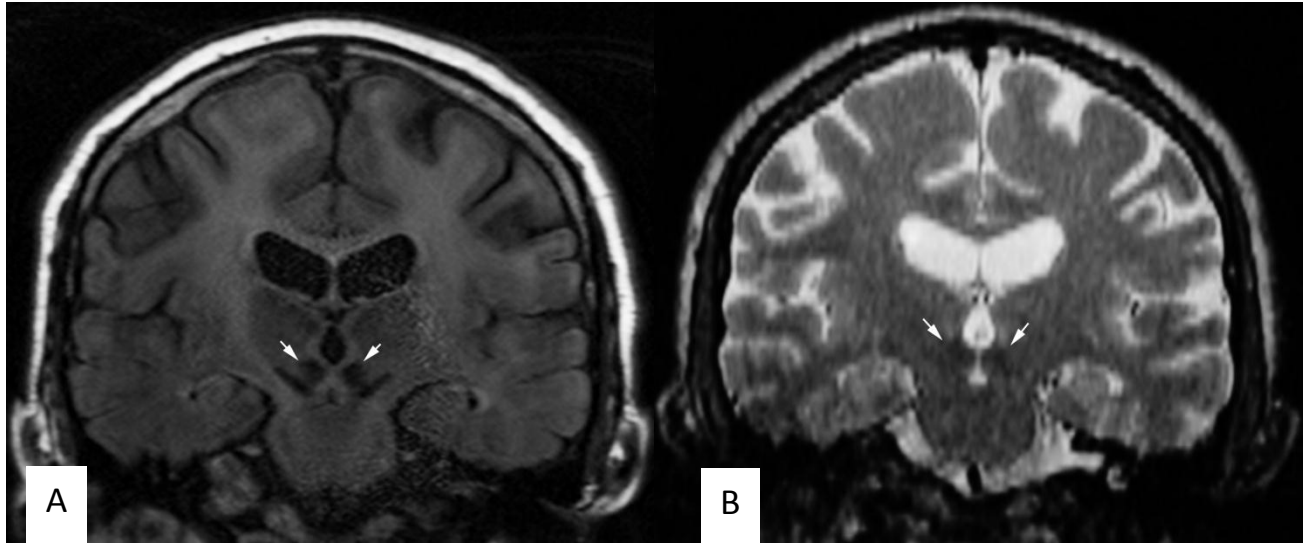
Comparison of coronal 3T and 1.5T MRI images for RN visualization in the same patient. The RN is well visualized at both 3T (A) and 1.5T (B). By contrast the STN and SNR are only well visualized at 3T.
